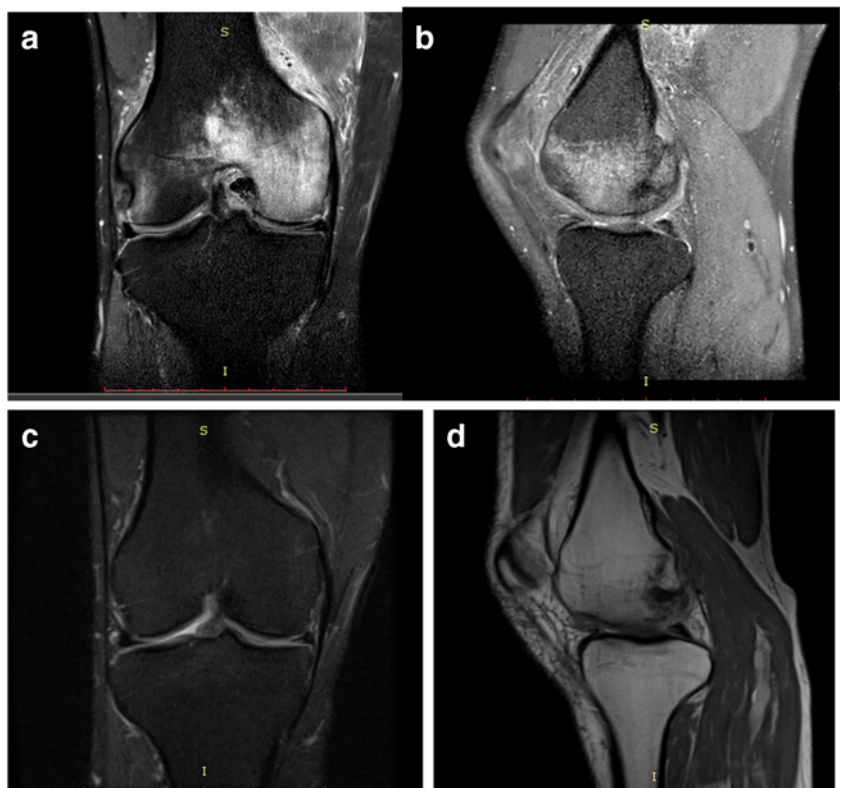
a and b present MRI scans taken 6 months apart in the same patient without treatment
